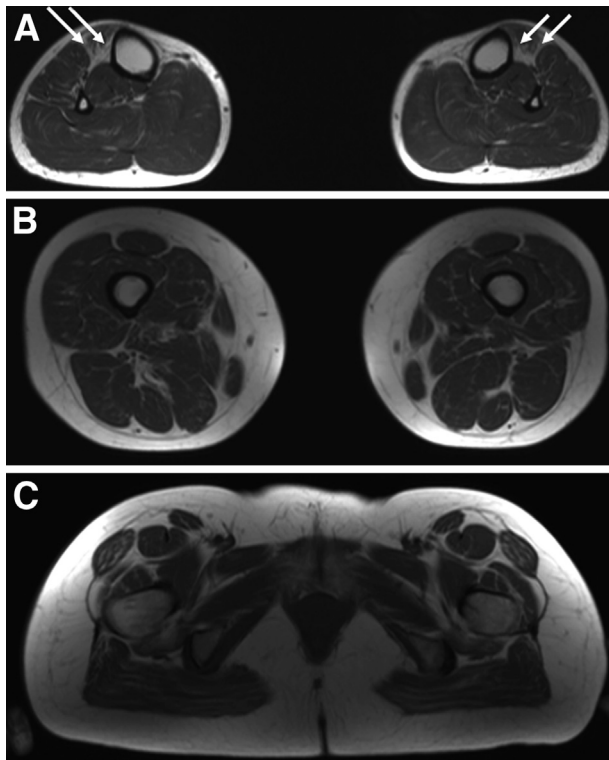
Selective dystrophic involvement of muscles in a 39-year-old female Laing distal myopathy patient caused by dominant mutation K1729del in exon 36 of the *MYH7* gene. A: Magnetic resonance images show replacement with fatty connective tissue in the tibialis anterior and extensor hallucis longus muscles in the lower legs (arrows). B and C: No major changes are discerned in the thigh (B) and pelvic muscles (C).
